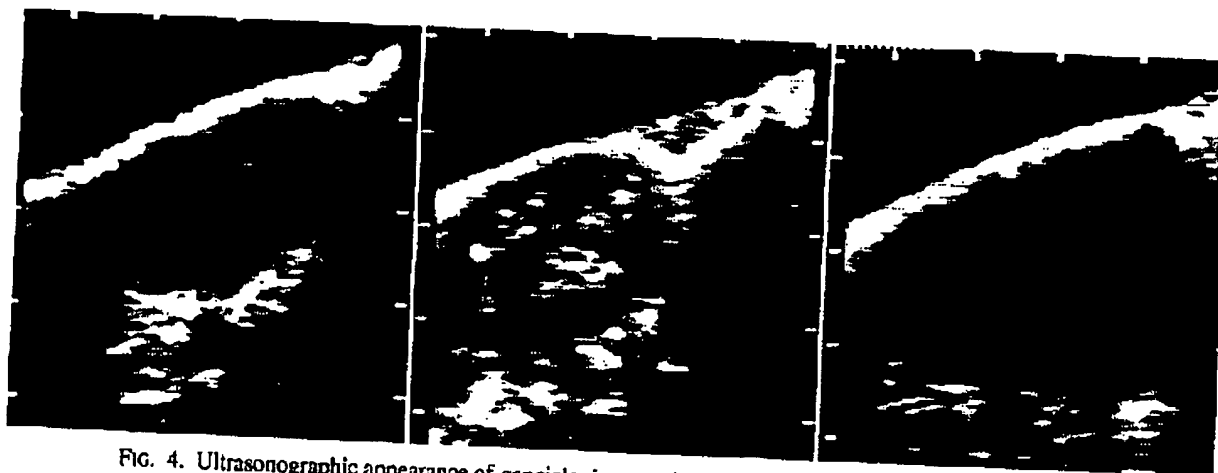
Ultrasonographic appearance of ganciclovir-treated subcutaneous tumors at various phases of treatment. Left: Before initiation of ganciclovir therapy, the tumor is homogeneous. Center: Seven days after initiation of ganciclovir treatment, there are multiple intratumoral hyperechoic signals representing hemorrhage sites. Right: On Day 14 after initiation of ganciclovir administration, multiple necrotic cavities are evident within the tumor.
